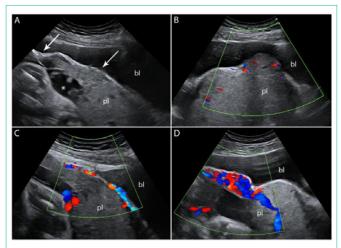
Transabdominal ultrasound at 30 weeks of gestation, A: Loss of hypoechoic plane in myometrium underneath the placental bed, reduced myometrial thickness, interruption of the bladder wall (arrows), abnormally large and irregular placental lacunae (asterisk), and B: Placental tissue bulging into the bladder. Colour Doppler reveals, C: Bridging vessels extending from placenta into bladder wall and (D) uterovescical hypervascularity. pl = placenta: bl = bladder.
